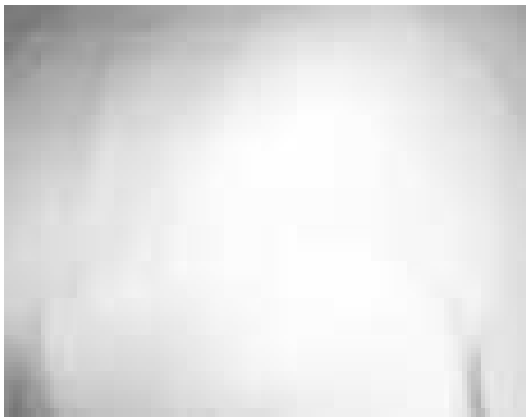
Test data for surface interpolation. (a) Original CT data set. (b) Detail of the test surface with an artificial defect superimposed. (c) Depth-map corresponding to (b).
